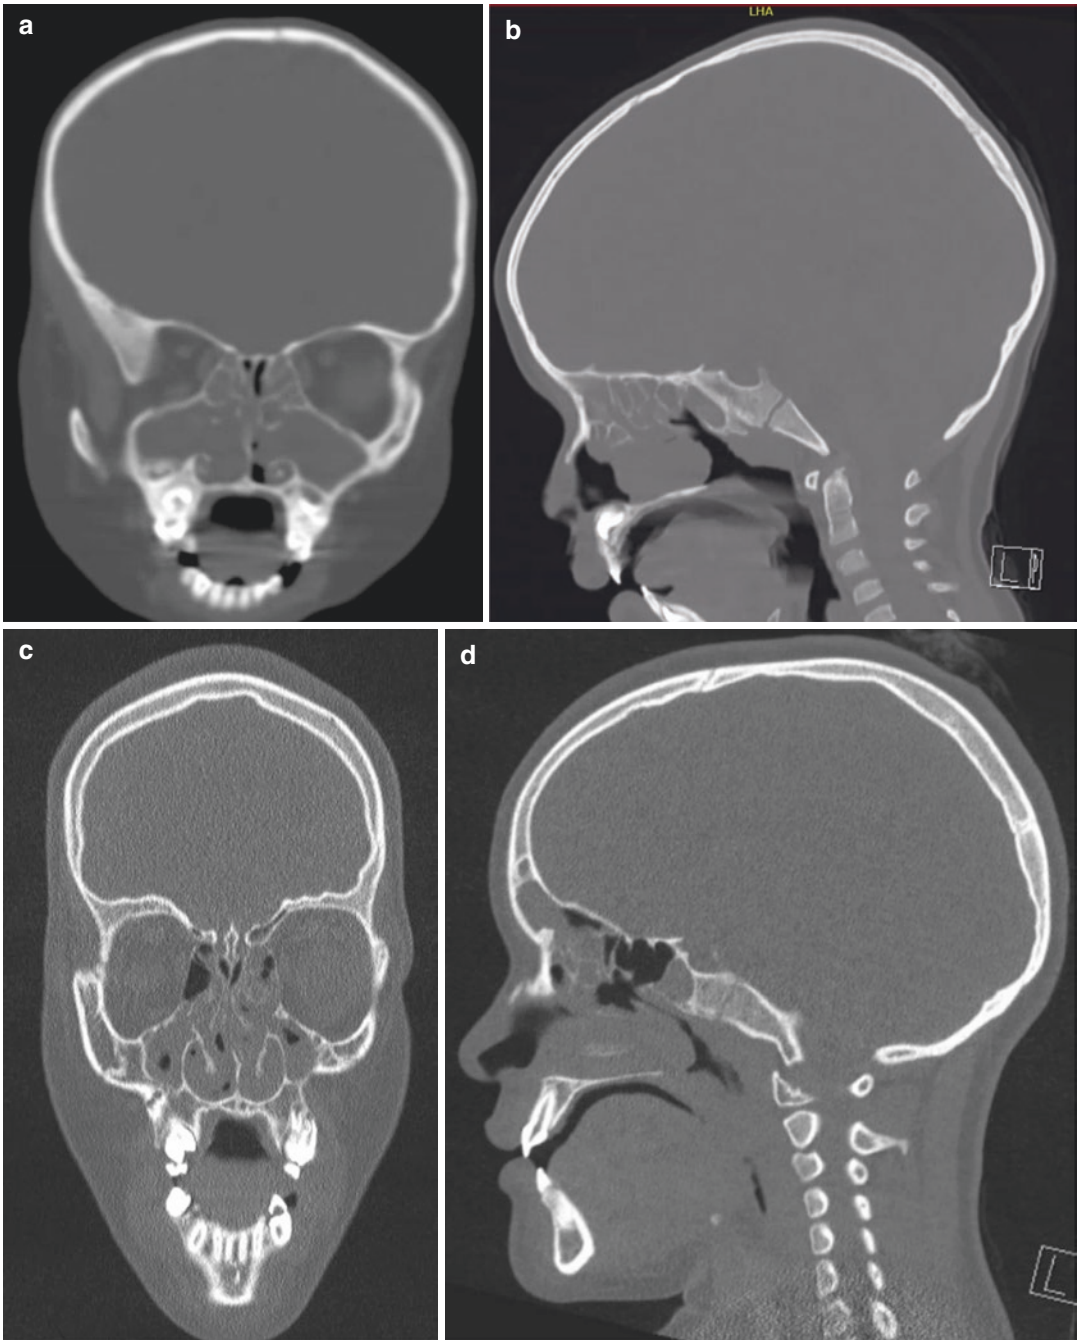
Computed tomography scans (CT scan) from children with chronic rhinosinusitis. (a) Coronal image of cystic fibrosis patient (5 year old) with polyposis. (b) Sagittal view of same patient, the sphenoidal is underdeveloped as well as the frontal sinus. (c) Coronal view of a 12-year-old with chronic rhinosinusitis with no polyposis. (d) Sagittal view of same patient of (c)
